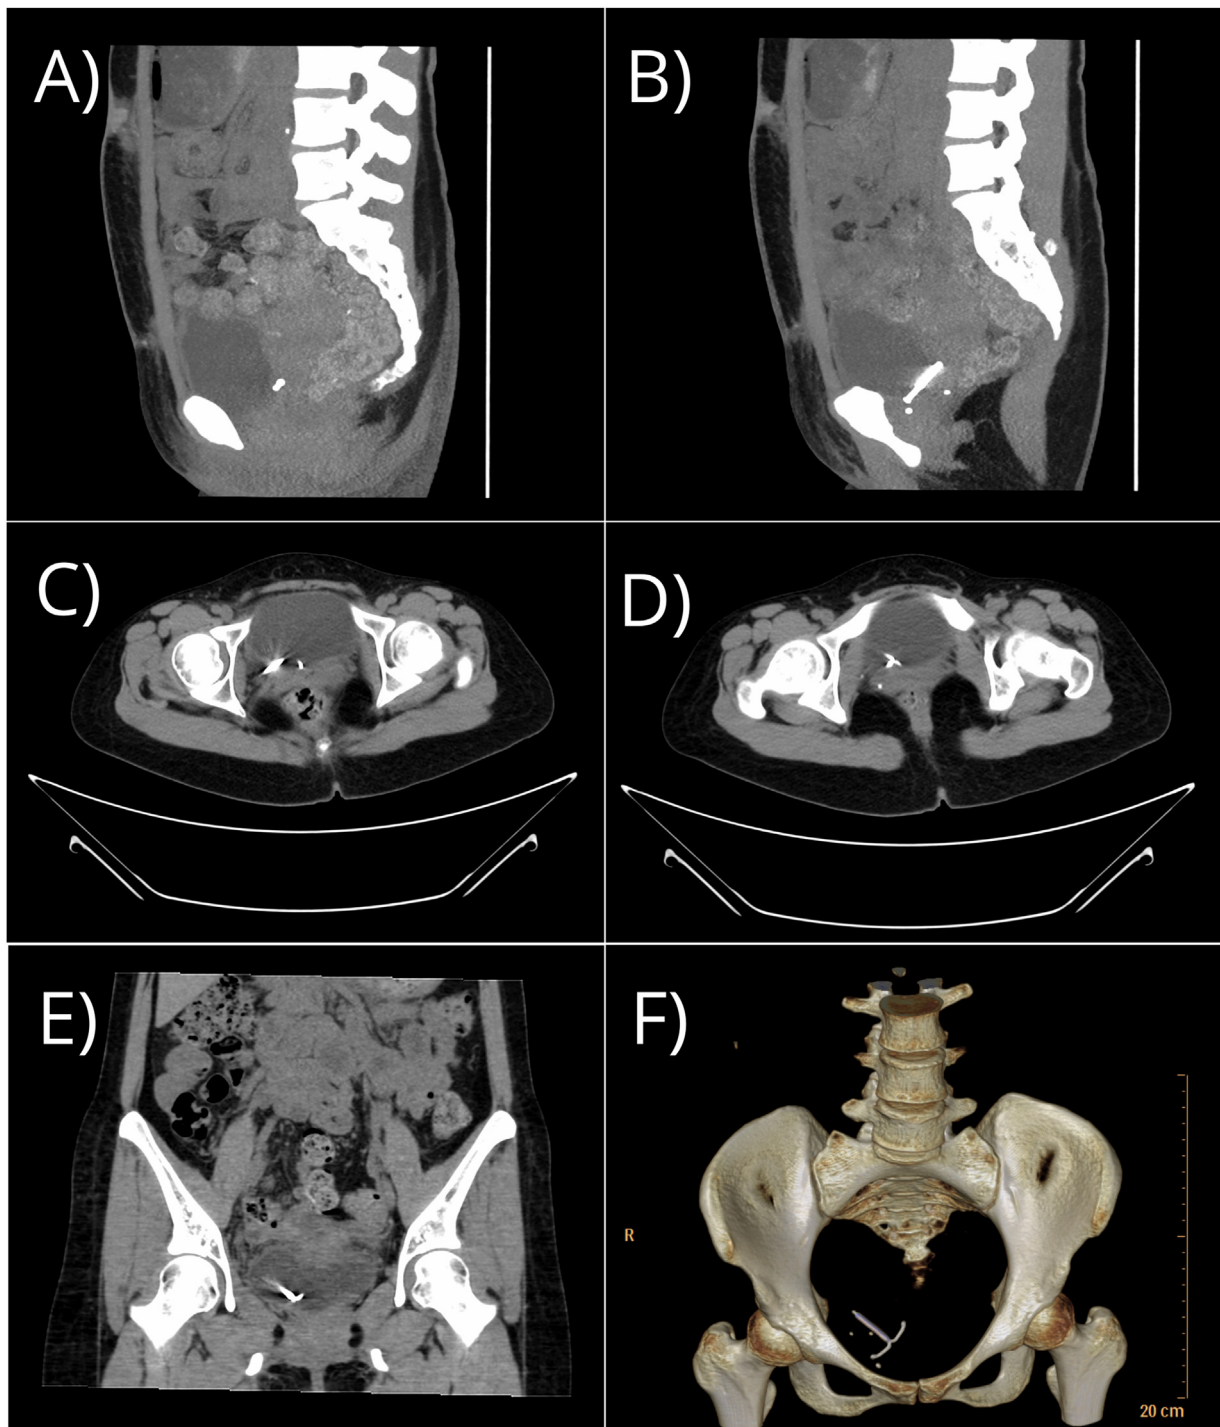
Computed tomography (CT) scan of the pelvis 1 month after intrauterine device (IUD) insertion. (A) Sagittal view of the pelvis showed an embedded tip inside the bladder wall (B) Sagittal view of the pelvis showed that the IUD was mostly inside the bladder (C) Transversal view of the pelvis showed two tips embedded in the bladder wall (D) Transversal view showed that parts of the IUD were inside the bladder (E) Coronal view showed that the IUD was inside the bladder (F) 3D scheme showing that the IUD was still in the pelvic area.
